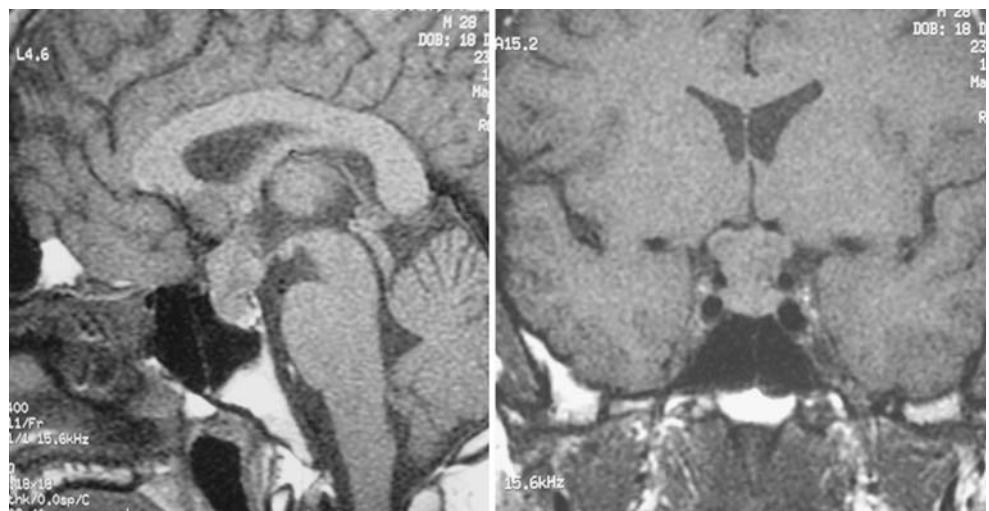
MRI sagittal (*left*) and coronal (*right*) T1WI views with IV gadolinium showing strong heterogeneous contrast enhancement
